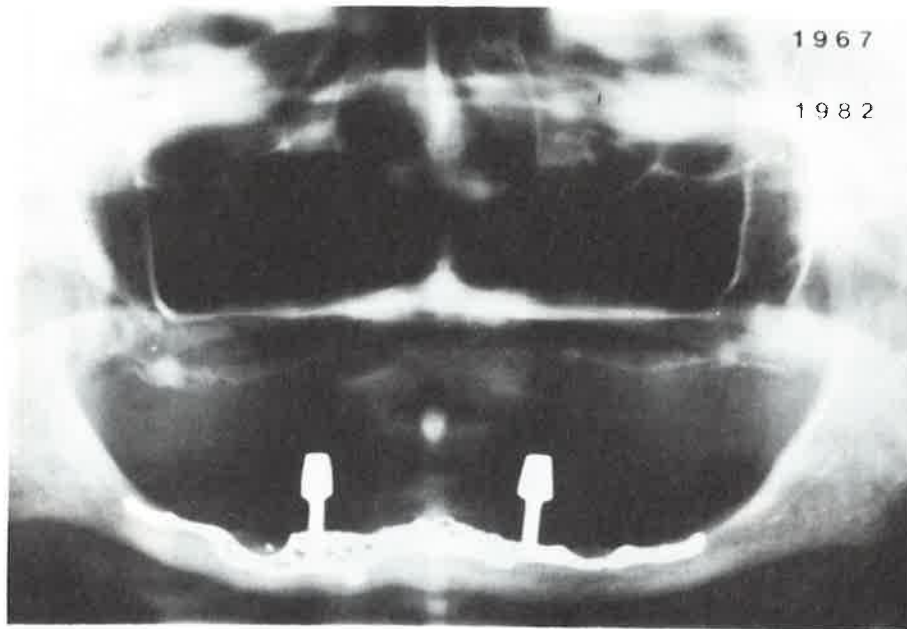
Radiograph of subperiosteal implant 15 years after insertion. Courtesy of Dr N. Berman, Private Practice, Seattle, Washington, USA.
